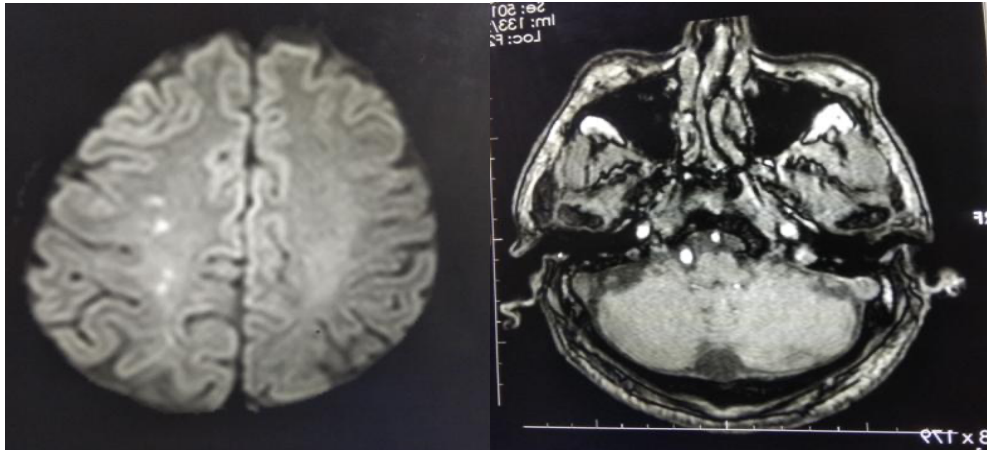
DWI MRI Images showing acute right MCA territory infarcts
